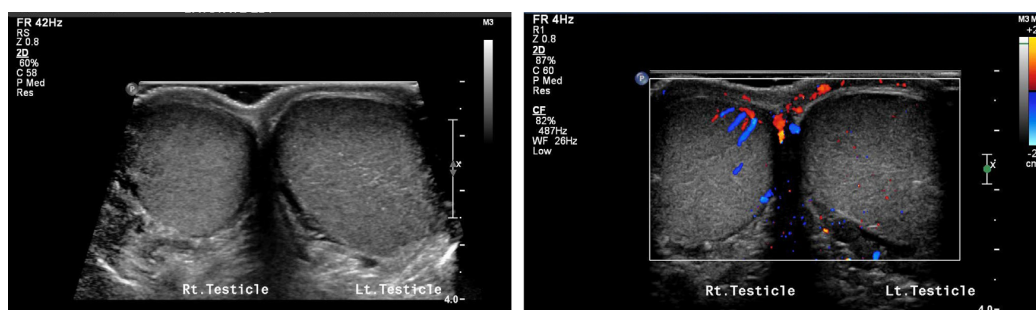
Testicular torsion: asymmetric enlargement of the left testicle on gray scale. No internal color flow is seen in the left testicular parenchyma on color Doppler interrogation. (Color version of figure is available online.)
